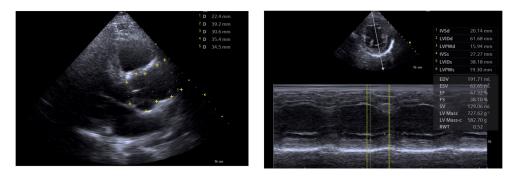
b.23. Left: aortic measurements (aortic root, aortic ring, Valsalva sinuses, sino-tubular junction, ascending aorta; 2D-parasternal long axis); right: LV measurements (interventricular septum, posterior LV wall and LV diameters during cardiac cycles (M-mode, parasternal short axis, middle section).
